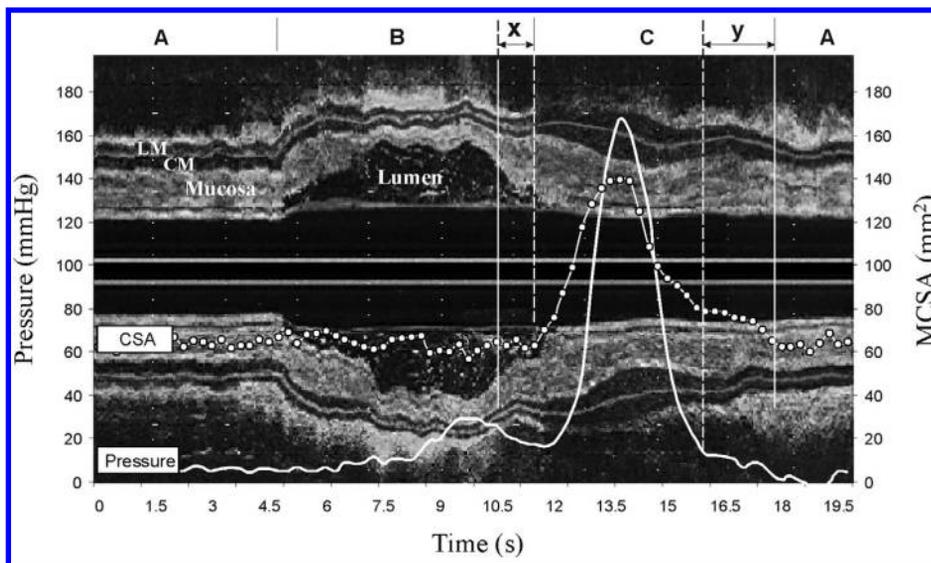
Coordination of esophageal circular and longitudinal muscle during peristalsis. M-mode echo-esophagram with superimposed, intraluminal pressure and muscle cross sectional area (MCSA) during 5 ml water swallow; ultrasound transducer positioned 2 cm above the lower esophageal sphincter. A: baseline esophagus, prior to swallow; B: bolus induced distension—bolus pressure, thinning of mucosa and muscle layers; C: esophageal contraction. Note the dissociation between increase in MCSA and increase in intraluminal pressure. The increase in MCSA (—o—) begins before and outlasts the intraluminal pressure wave (—). The difference between the onset of CSA and pressure is due to the delay in recording circular muscle contraction by manometry. LM: longitudinal muscle, CM: circular muscle. (Source: Mittal et al., *Am J Physiol Gastrointest Liver Physiol* 2006;290:G431–8.)
